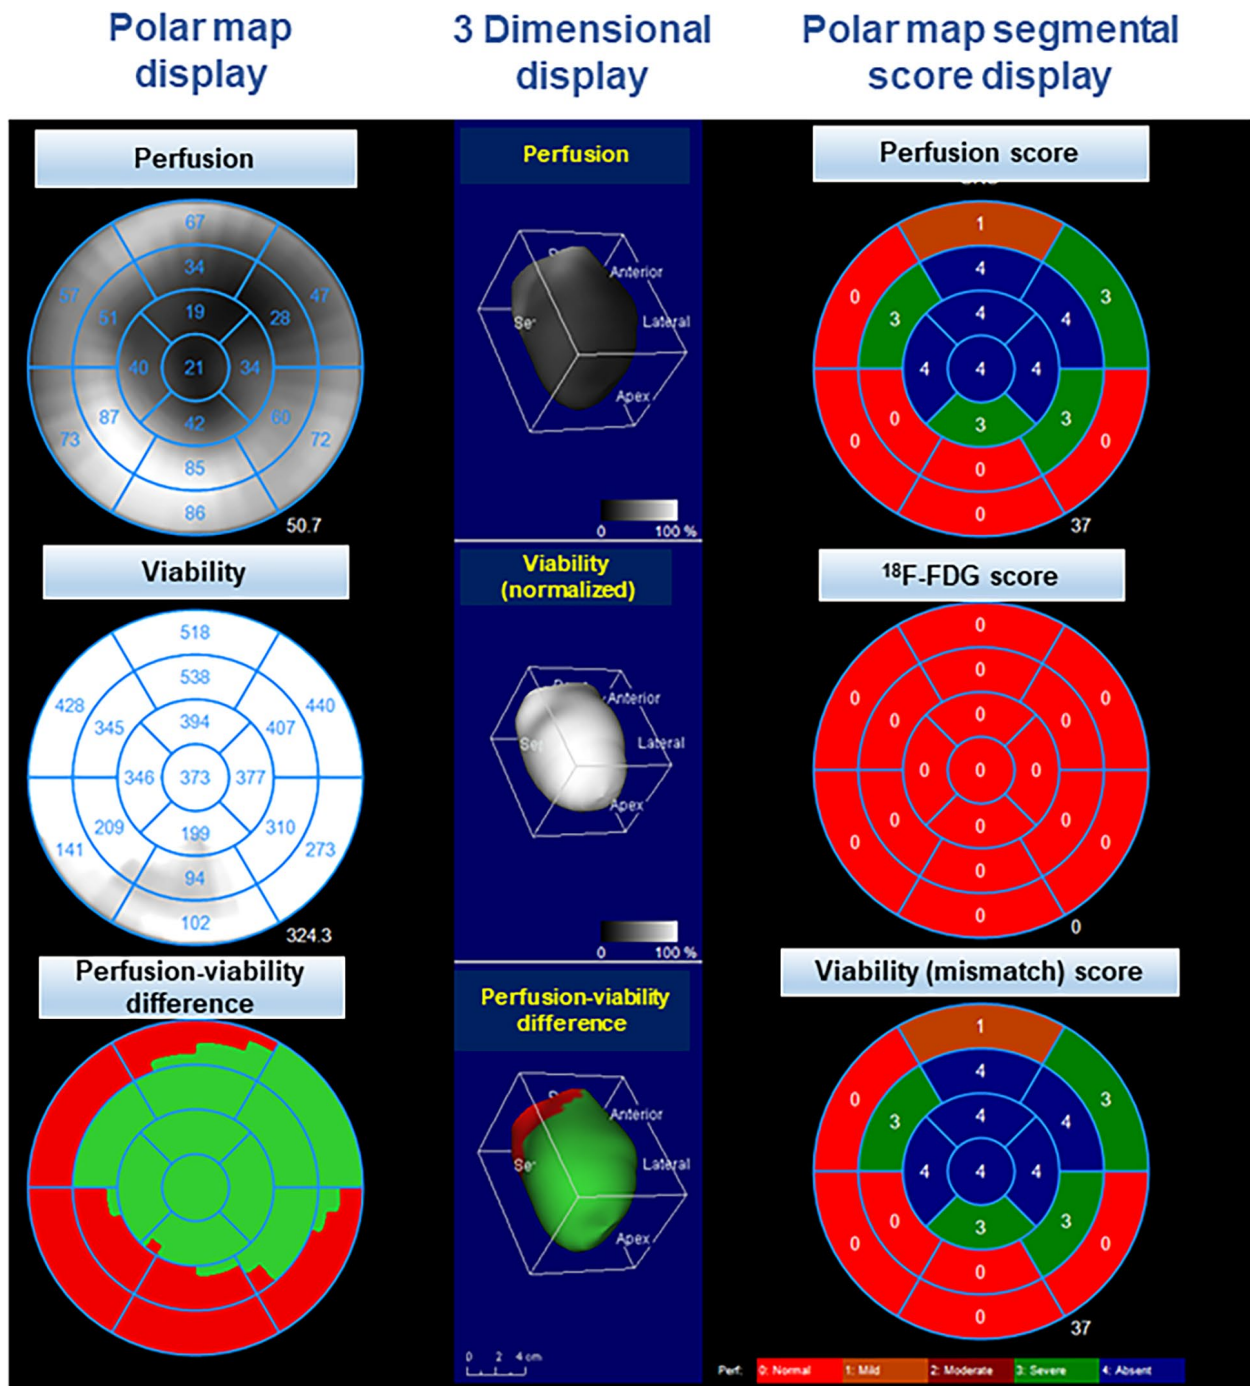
Corresponding to the images shown in Figure 3, the polar map and three-dimensional display of the rest myocardial perfusion SPECT/CT images with ^{99m}Tc-tetrofosmin and ¹⁸F-FDG PET/CT images in a patient with dilated ischemic cardiomyopathy, demonstrate a “mismatch”.
